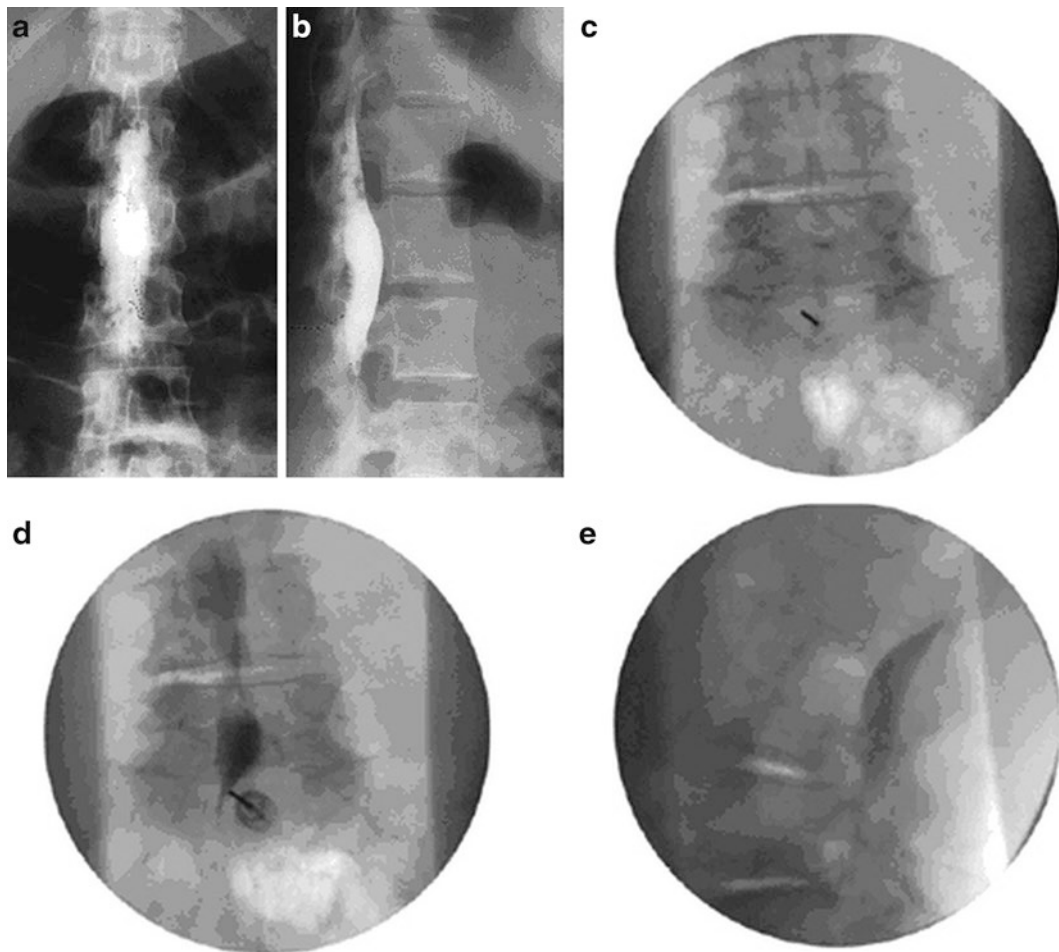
Subdural contrast patterns. (a, b) Typical subdural compartment with contrast filling. (a) PA radiograph of the lumbar spine with subdural contrast media. The dense collection of contrast media is confined to the central portion of the spinal canal and does not extend to outline the exiting spinal roots laterally or in the inferior portion of the thecal sac. (b) Lateral radiograph of the lumbar spine with subdural contrast media. The dense collection of contrast media is confined to
